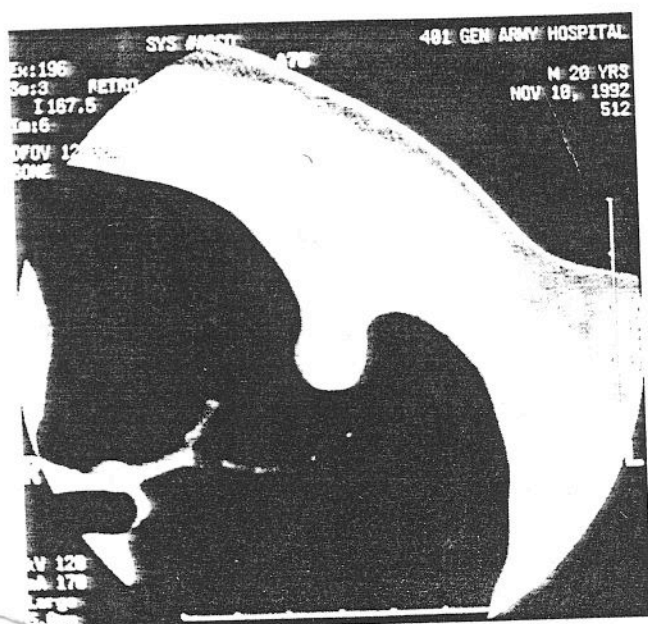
Chest CT scan of a 21-year-old patient showing osteochondroma of the 3rd left rib.
